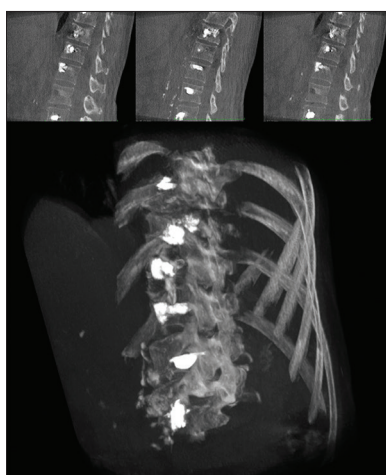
Postoperative spine cone-beam computed tomography with three-dimensional reconstruction
